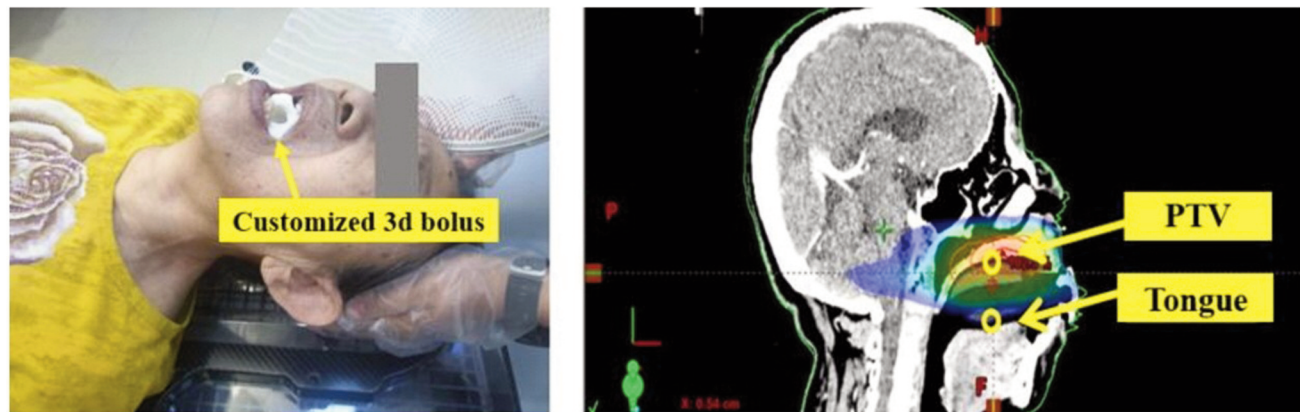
Treatment setup and planning for patient 2. (a) Treatment setup and applying the customized 3D bolus made to patient 2, (b) a sagittal CT image taken with a balloon injected with 50 ml air in the mouth.
